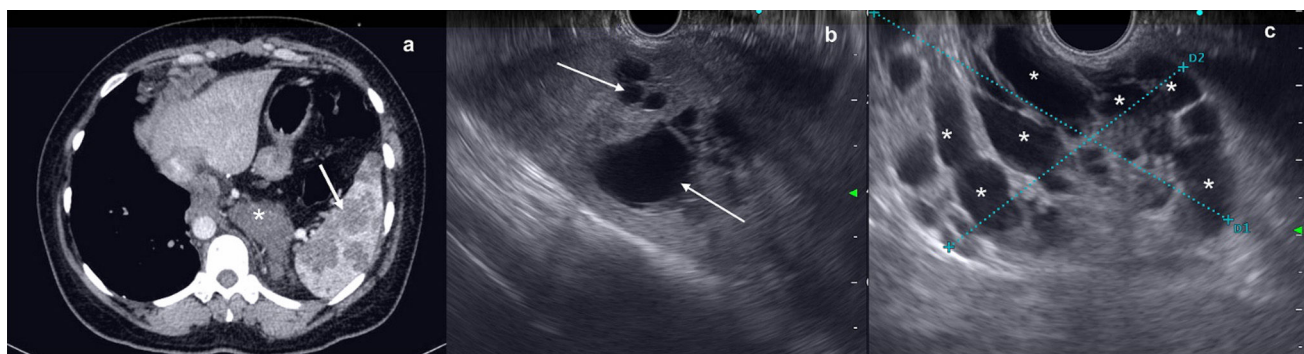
a) Abdominal CT scan showing multiple rounded lesions in the spleen (arrow), as well as a lesion at the level of the body and tail of the pancreas (asterisk), all with a cystic aspect. b) EUS showing rounded anechoic lesions in the spleen (arrows), consistent with cysts. c) EUS showing cystic lesions in the tail and body of the pancreas (asterisks).
